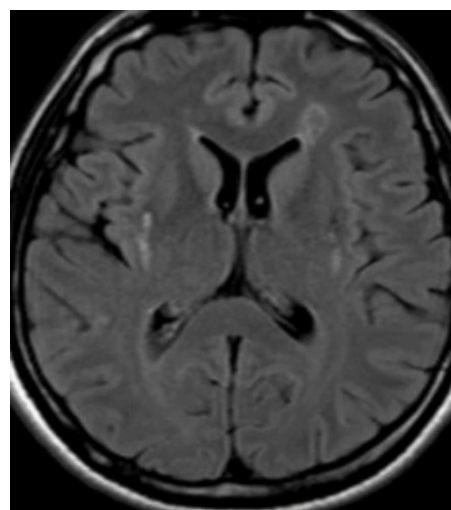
Bilateral putaminal volume loss in chronic period flair MRI, lesions accompanied by hemosiderin pigments and gliosis, and hyperintense lesion in the left frontal subcortical white matter
